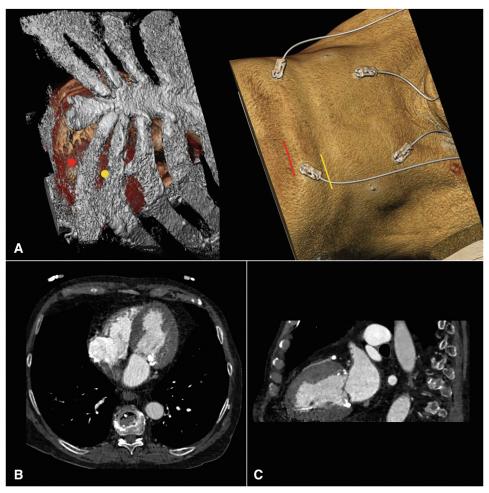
Calculated (*yellow*) and actual target site (*red*) as well as corresponding skin incisions for transcatheter mitral valve replacement in 3D-CT scan (A) presentation of the heart in the transversal (B) and sagittal plane (C) of the 2D CT scan. 2D, 2-Dimensional; 3D, 3-dimensional; CT, computed tomography.
